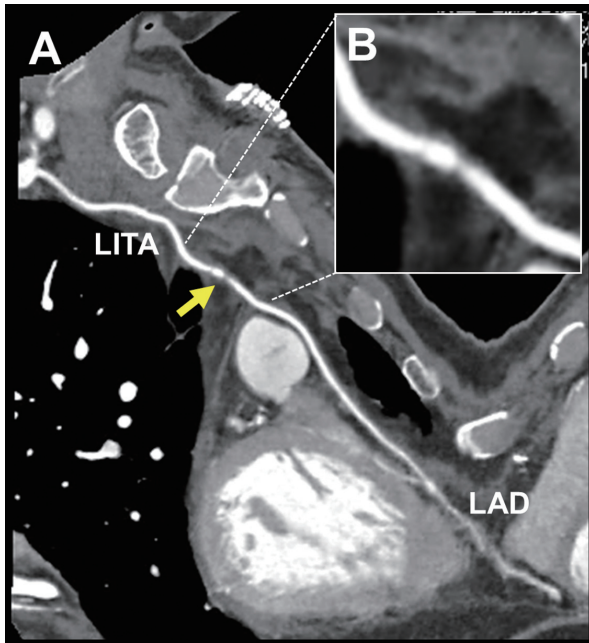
A: Computed tomographic angiography showed a focal stenosis (yellow arrow) in the mid-portion of the left internal thoracic artery (LITA) graft to the left anterior descending artery (LAD). B: Magnified image of a stenosis in the LITA graft.
